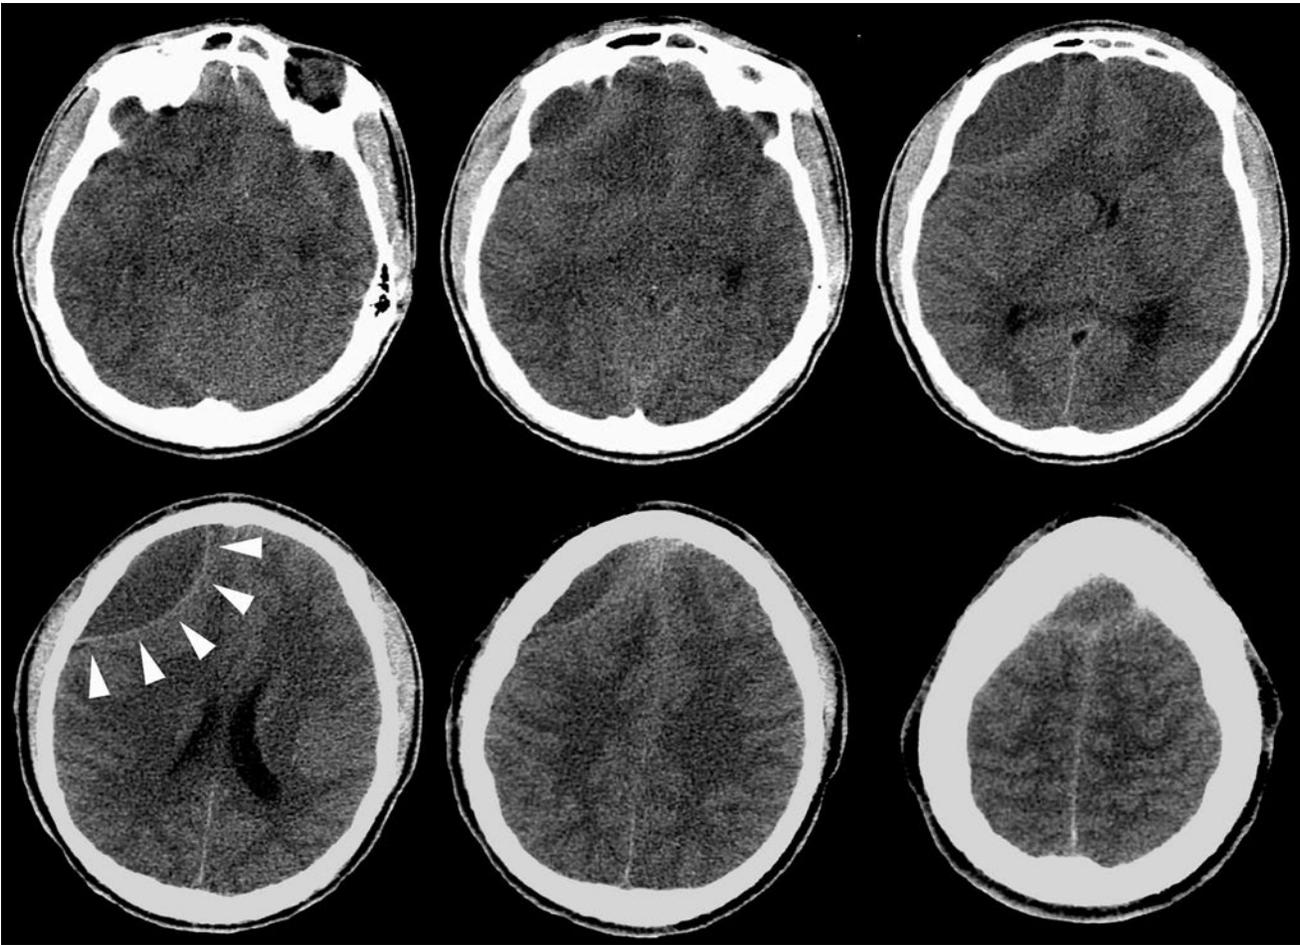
This computed tomographic scan of the brain without enhancement shows a large anterior fossa epidural abscess. White arrowheads mark the biconcave contour. This collection was drained successfully through an infraorbital incision and a bur hole in the right orbital roof.
